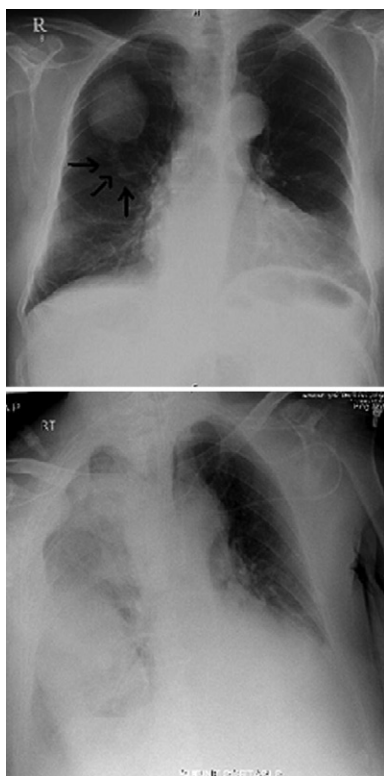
Chest X-ray before and after the cardiac arrest. Arrows on top X-ray showing one of the large feeding arteries.
